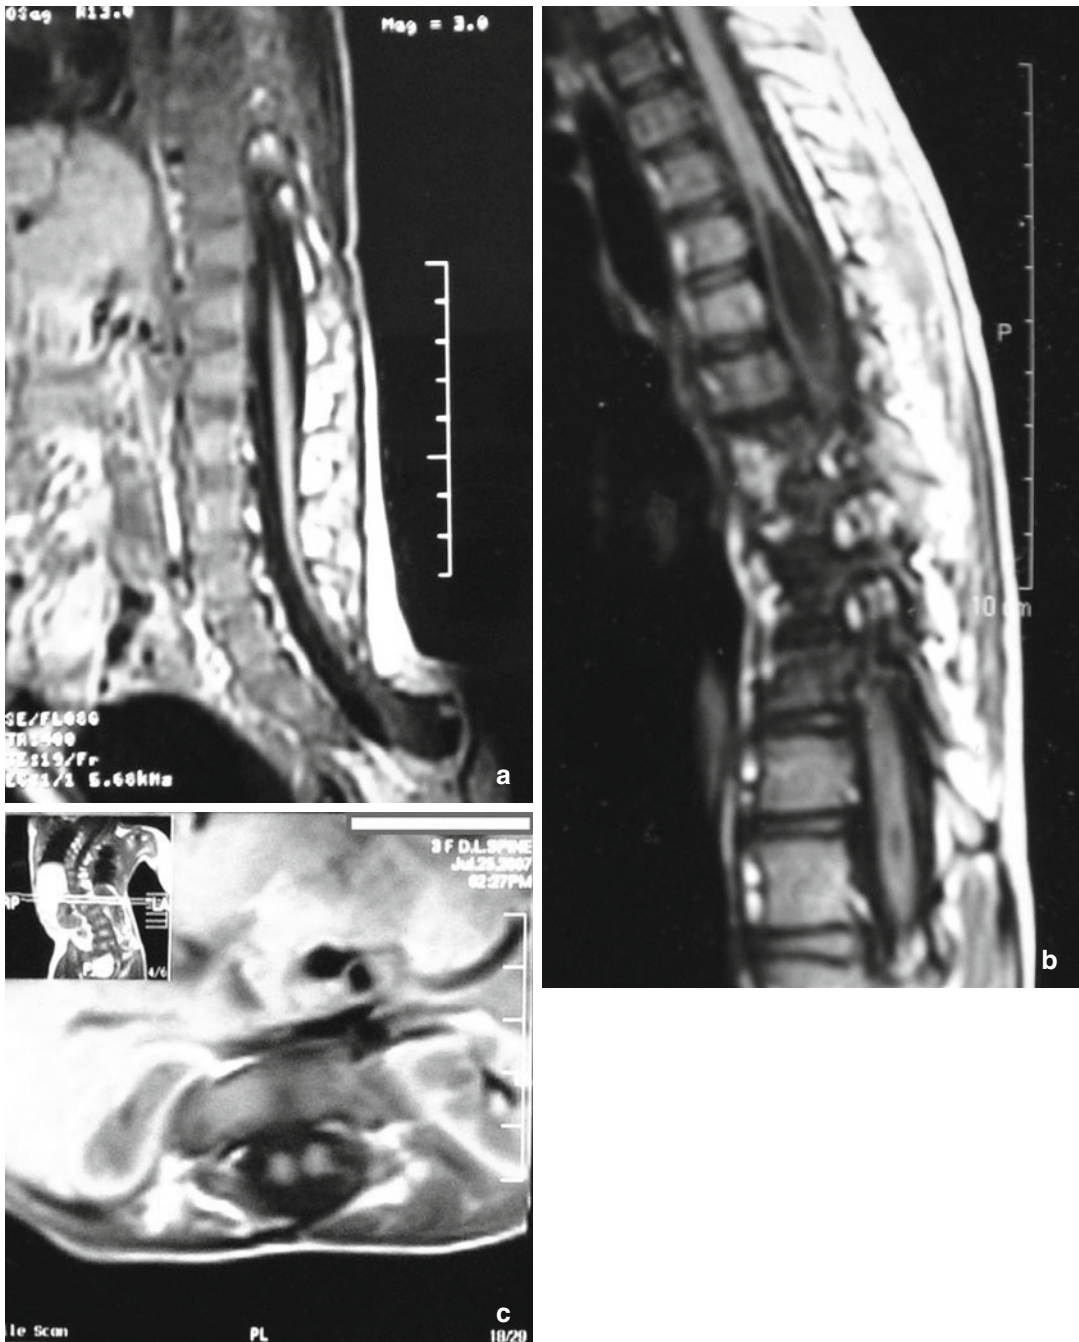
Intraspinal anomalies associated with spinal deformities requiring neurosurgical consultation. (a) A sagittal T1-weighted MRI showing a tethered spinal cord, the most common MRI-identified intraspinal anomaly in congenital spinal deformity. Syringa and tethered cord can also be found in case diagnosed as idiopathic scoliosis.
